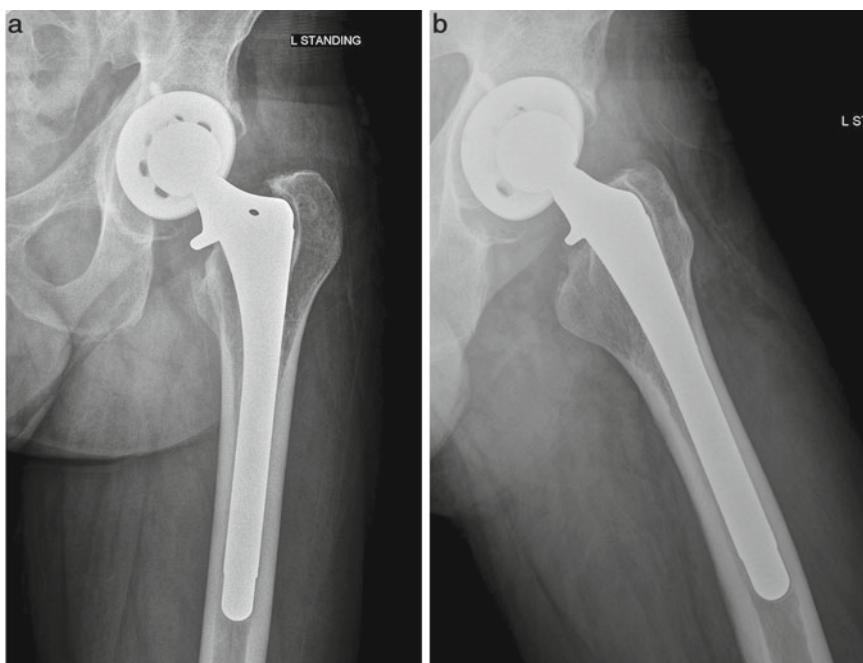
(a) AP and (b) lateral radiographs of a patient with loosening of the acetabular component secondary to a chronic low-grade PJI
